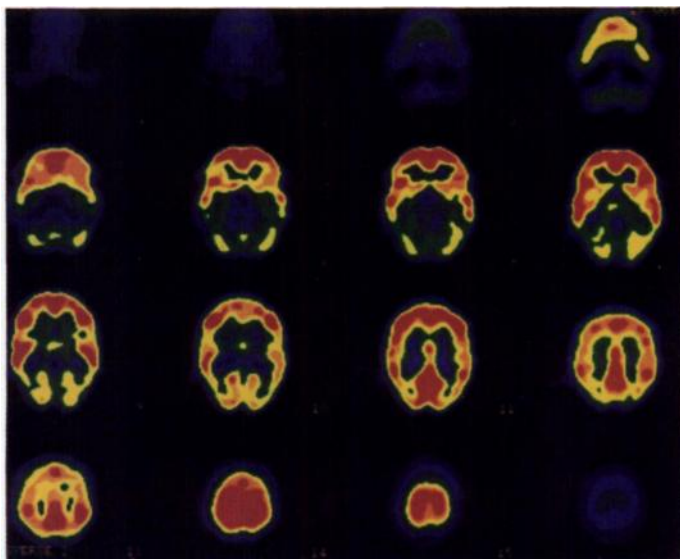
Fluorine-18-FDG study on second day of admission shows normal patterns. Frontal lobe glucose uptake is higher than that in parietal and occipital lobes.
